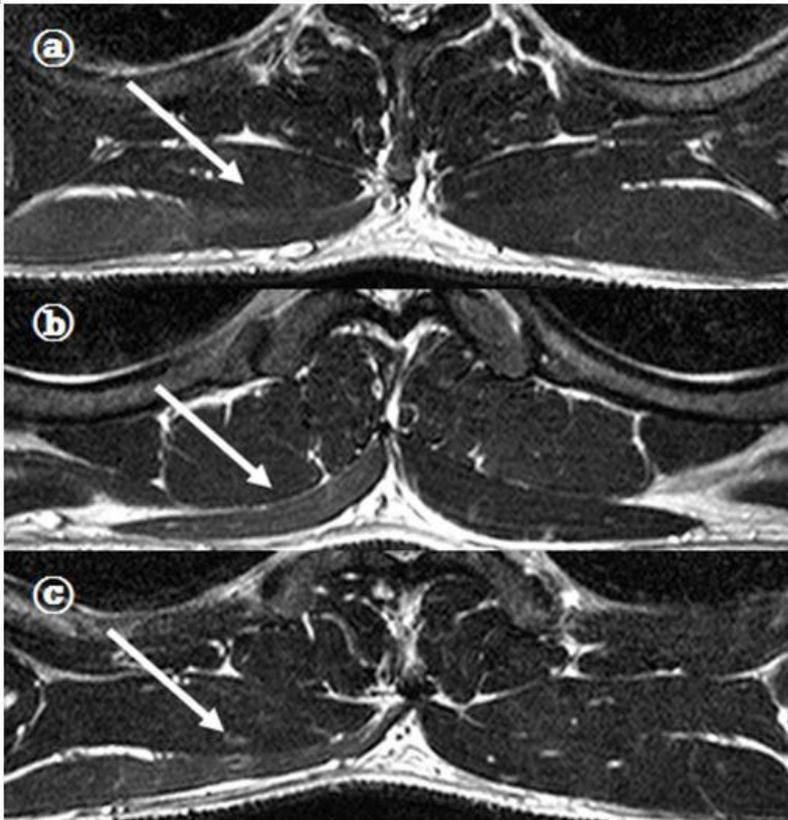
Transverse views of T2-weighted magnetic resonance imaging(MRI) reveal marked wasting in the muscle bulk of mid to lower part of the right trapezius (arrows). (a) T2 level, (b) T4 level, (c) T7 level.
